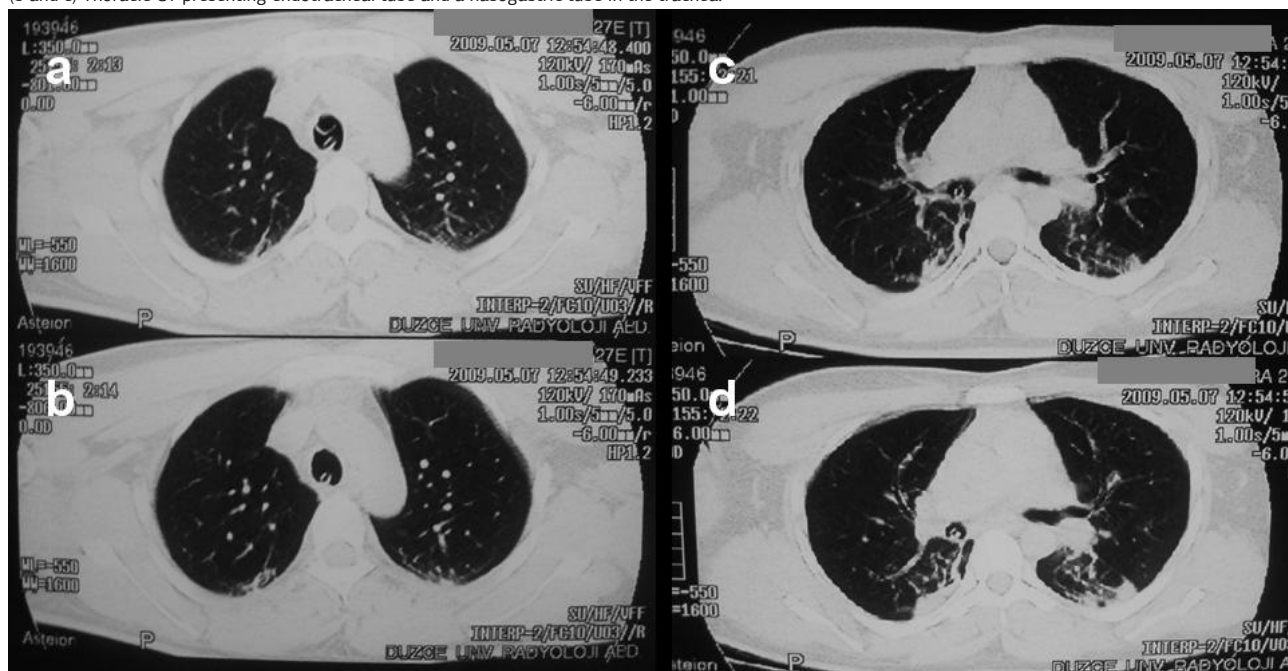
(a) Thoracic CT presenting endotracheal tube and a nasogastric tube in the trachea (b) Thoracic CT presenting nasogastric tube in the trachea (c) Thoracic CT presenting nasogastric tube in the right main bronchus (d) Thoracic CT presenting nasogastric tube in the intermediate bronchus.
